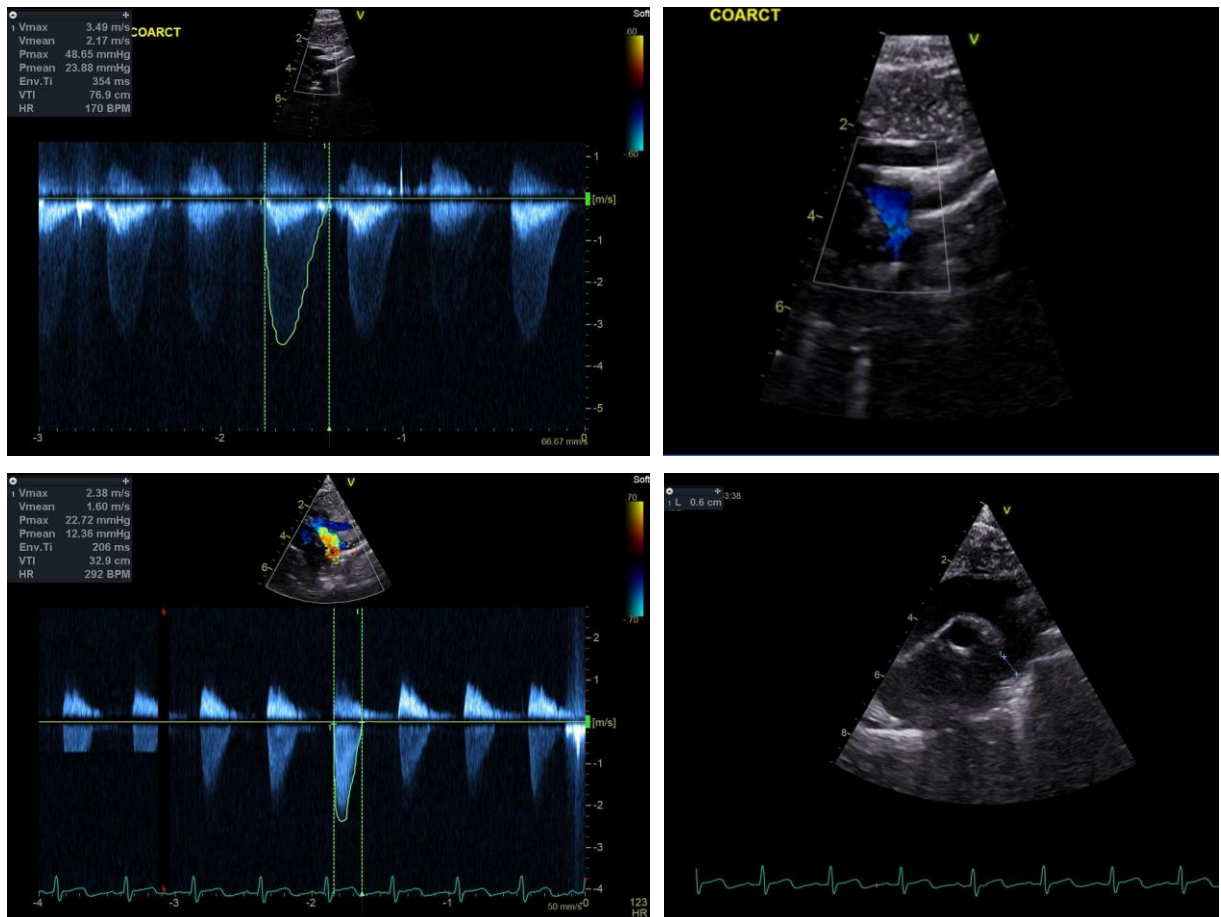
Coarctation zone echocardiography results for both pre- (top row) and post-intervention (bottom row) instances
